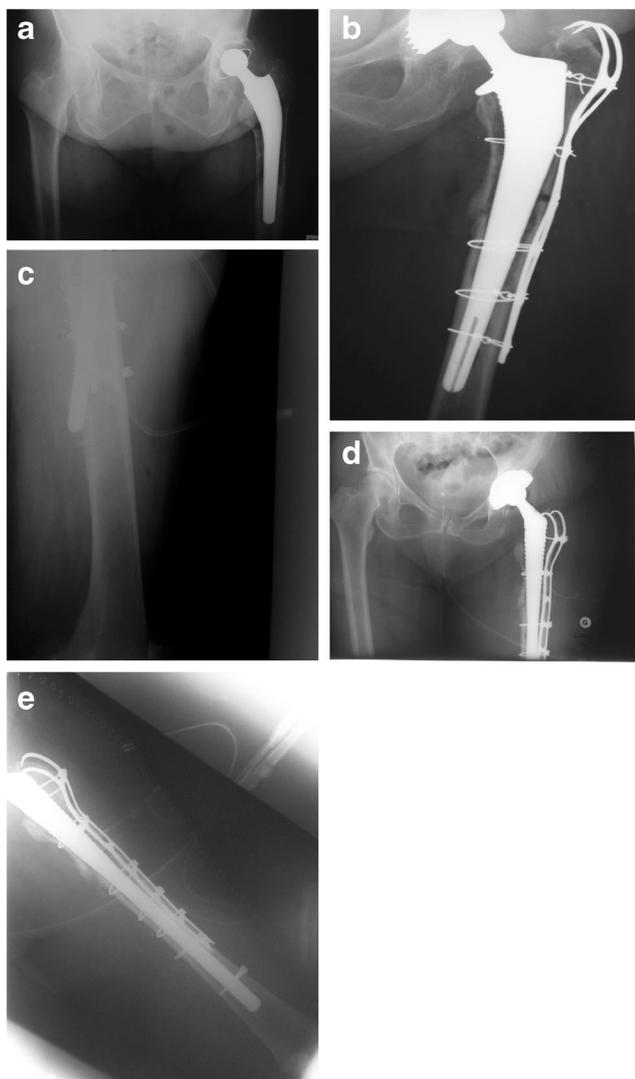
a Pre-operative radiograph of a 75-year-old female with stem aseptic loosening. b Immediate post-operative AP radiograph of Kar implantation. c Immediate post-operative lateral radiograph of Kar implantation (cortex perforation). d Stem revision using a locked modular stem. e Distal radiograph of the long locked modular stem
